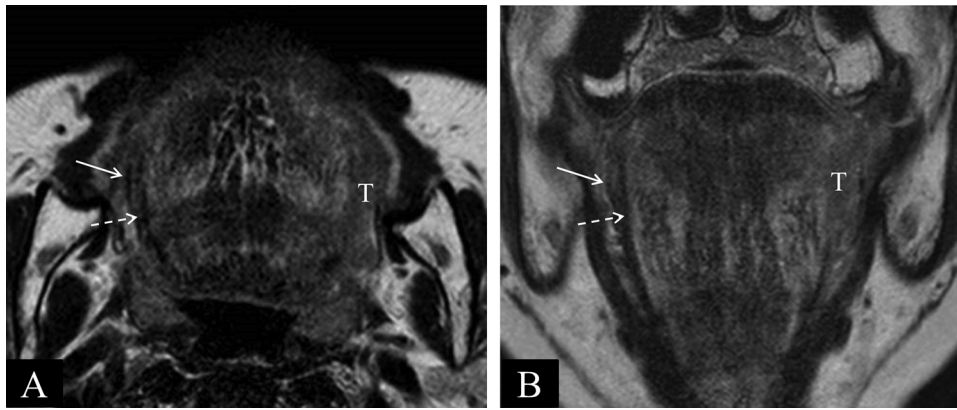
Findings of SHMI+. An 80-year-old male with left oral tongue squamous cell carcinoma. Axial T2-weighted images reveal oral tongue cancer invasion (T) to left styloglossus and hyoglossus muscle. The right styloglossus muscle (arrow) and hyoglossus muscle (dotted arrow) are normal.
